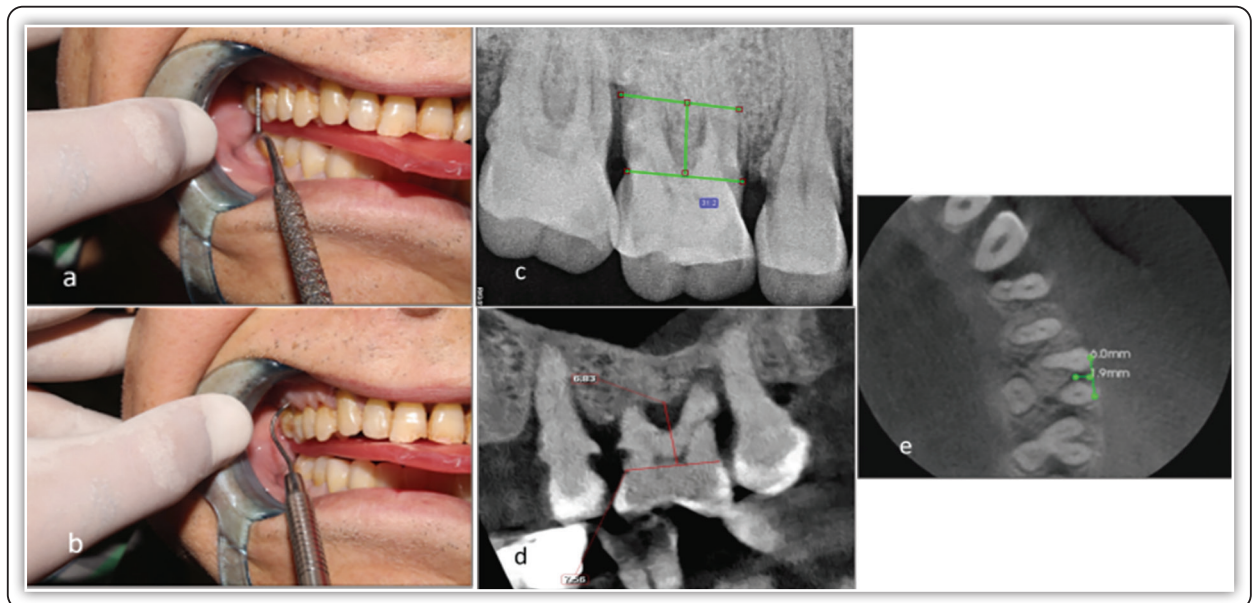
a. Intraoral clinical photograph detecting vertical furcation involvement of the maxillary right first molar using graduated periodontal probe. b. Intraoral clinical photograph detecting horizontal furcation involvement of the maxillary right first molar using Nabers periodontal probe. c. Intra-oral radiograph measurement of vertical component. d. Cone beam computed tomography measurement of vertical component. e. Cone beam computed tomography measurement of horizontal component.
